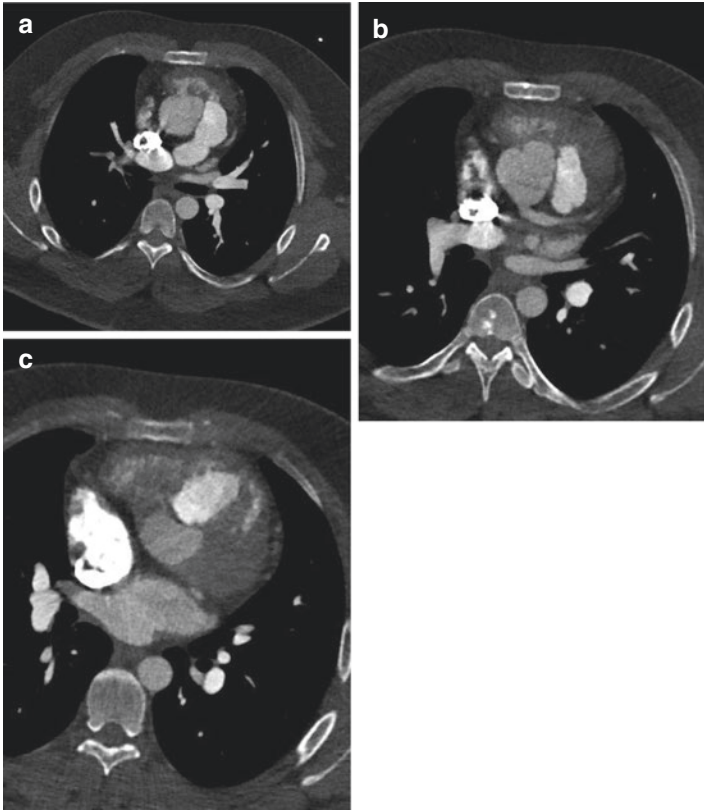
CT angiography images of double outlet right ventricle. Axial CTA images from the aortic and pulmonic root to the RVOT level (a–c serially in craniocaudal direction) showing both the aorta and pulmonary artery arising from RV
